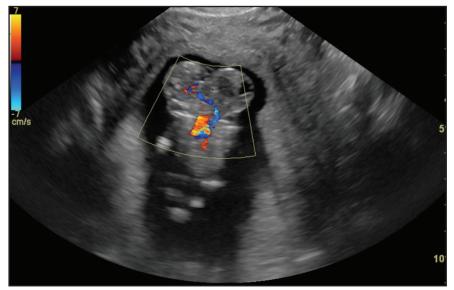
Coronal duplex Doppler transvaginal fetal ultrasound demonstrates a single heart with shared intracranial vasculature.
